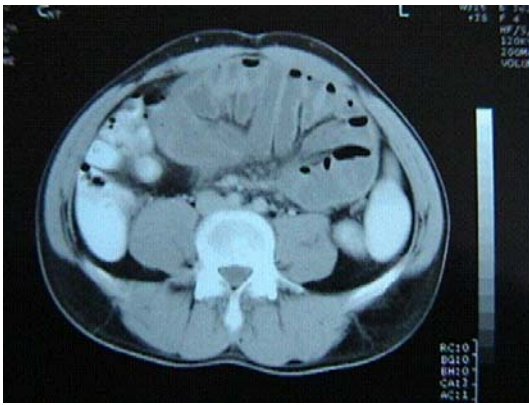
CT view of encapsulated small bowel
